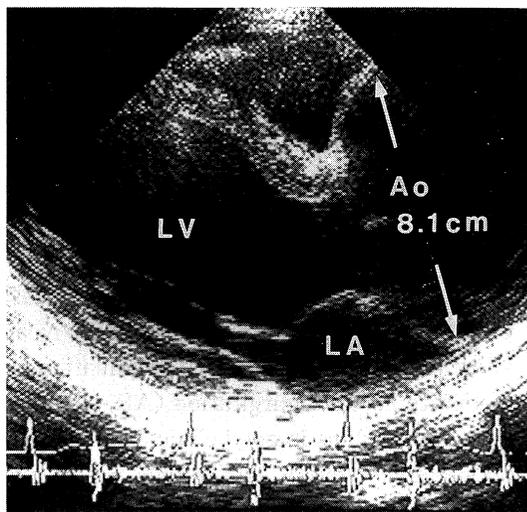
Two-dimensional echocardiograph.
